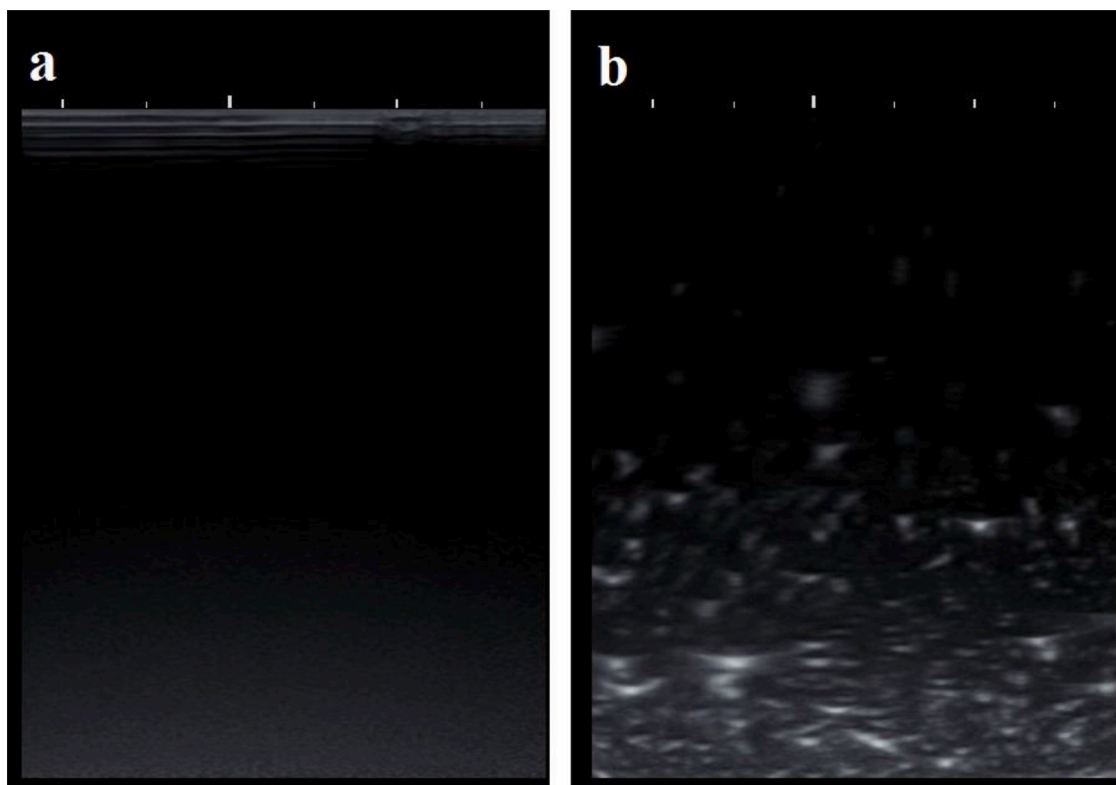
Ultrasound imaging of (a) PBS (control), and (b) Gd-DOTA/DOX NDs after injection into PBS.
